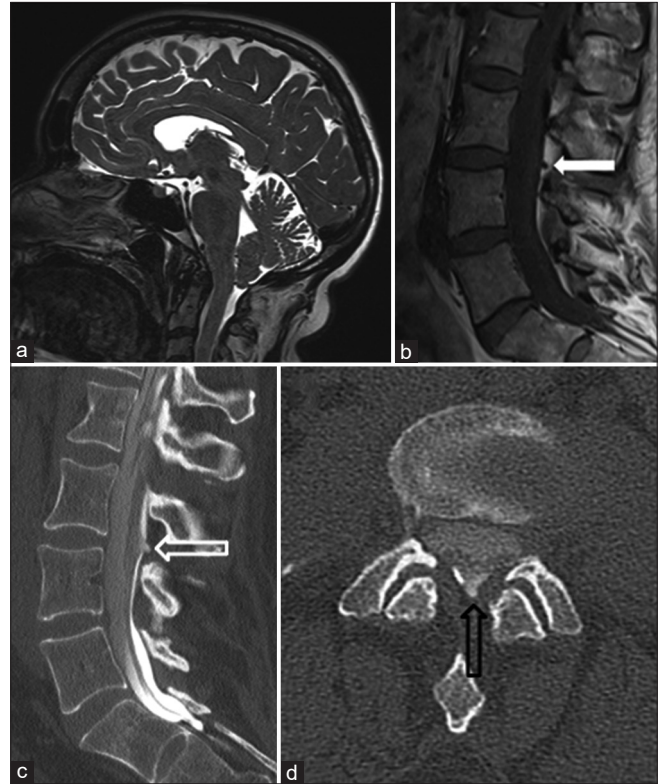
(a) Sagittal T2W MRI scan showing tonsillar descent with effacement of cisterna magna. (b) Sagittal T1W MRI reported as normal but reveals dural defect (white arrow) at L3/4. (c) Sagittal CT myelogram showing a posterior dural outpouching at L3/4 (hollow white arrow). (d) Axial CT myelogram view of same central dural defect at L3/4 (hollow black arrow).
